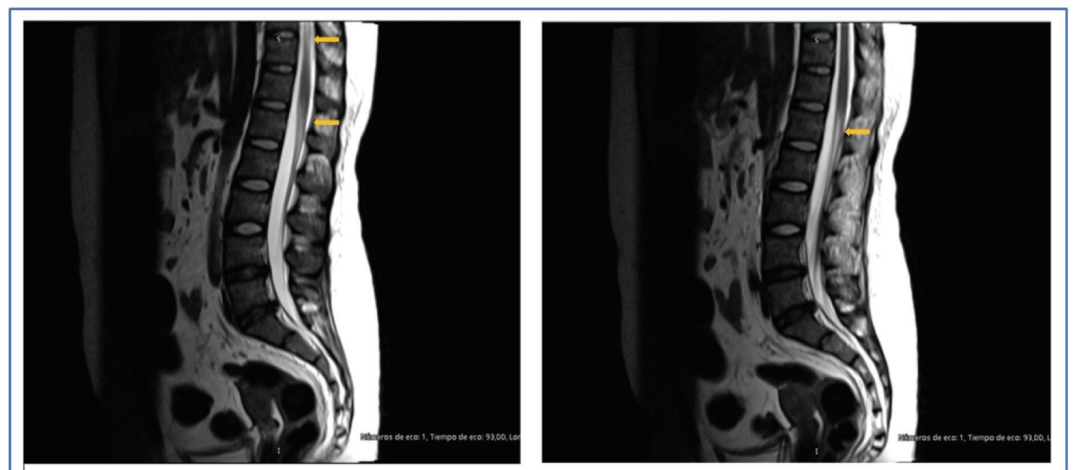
MRI shows hyperintense dorsolumbar spinal cord segments corresponding to demyelinating lesions involving more than three segments (T10-T11, T12-L1, and L1-L2).
